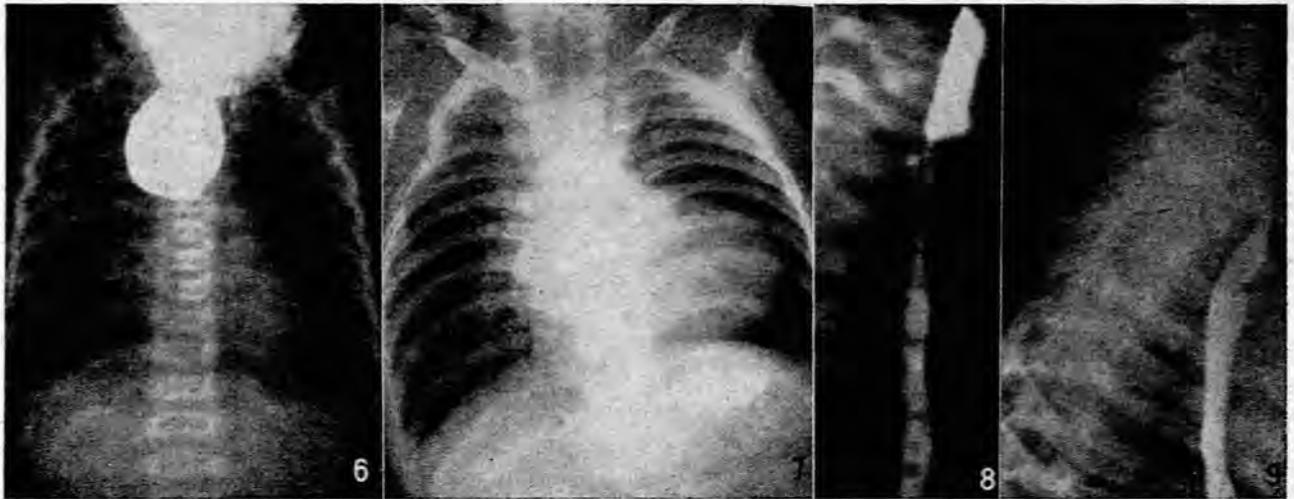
Radiograph from an early case showing gross over-distension of pouch with lipiodol.
